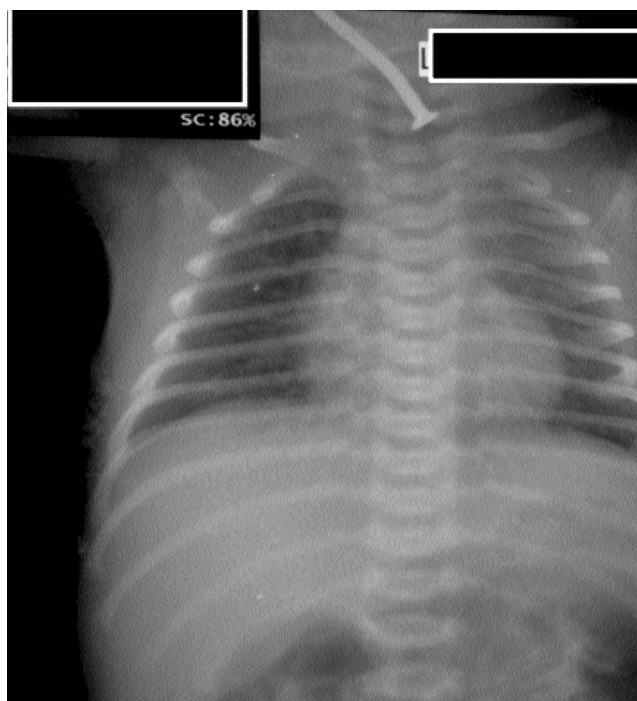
Plain radiograph showing nail in the neck.
